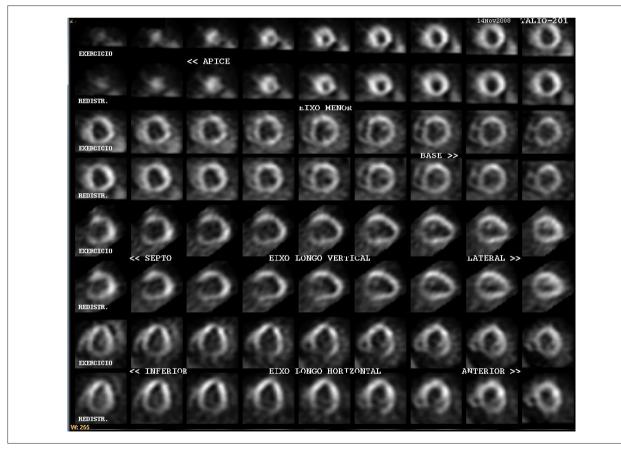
Myocardial perfusion scintigraphy with thallium-201. Homogeneous captation and dilatation of the left ventricle.
